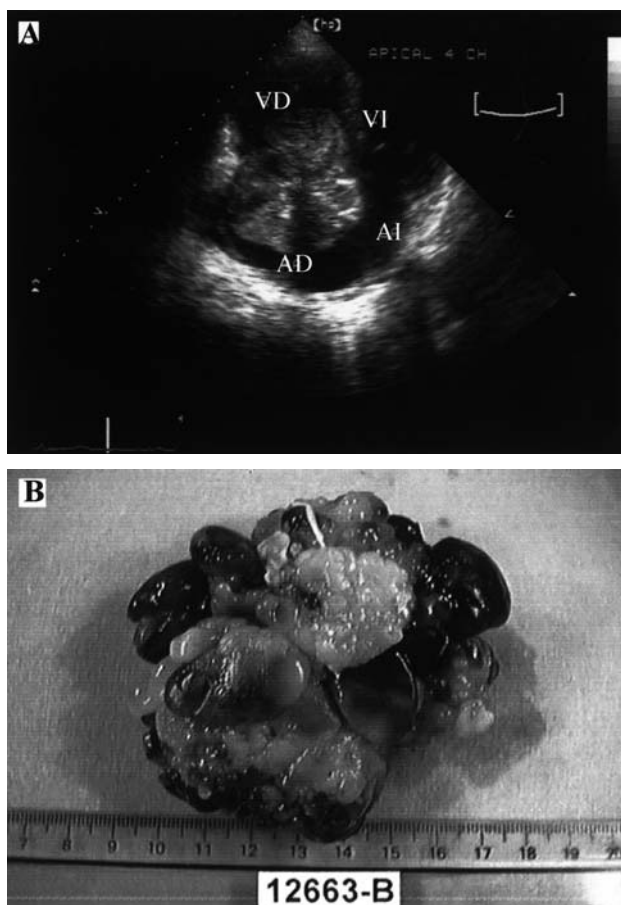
A: 2-dimensional apical 4-chamber echocardiogram. A large lobular non-homogenous tumor mass can be seen in the right cavities with converging tracts resembling a clover occupying the right atrium (RA) and part of the right ventricle entrance (RV). B: myxoma corresponding to the patient imaged in 3A. A tumor weighing 105 g and measuring 7.5 cm in diameter, papilla-derived, soft, with areas of whitish-yellow matter and hemorrhagic material.
